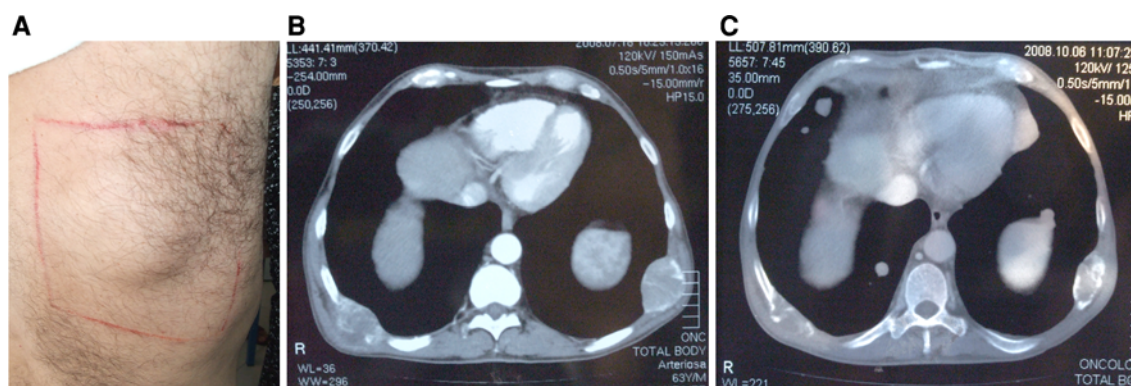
Clinical (a) and CT (b) images of rib involvement by tumor. In b CT shows metastases located at VI rib at the *left* and VII at the *right*. c shows the same lesions after zoledronic acid treatment
